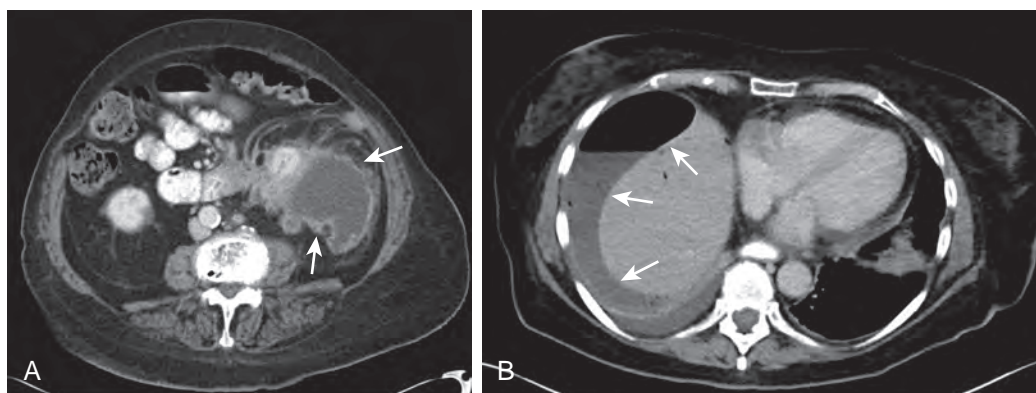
CT features of intra-abdominal abscesses in two different patients. A. Axial CT image in a 62-year-old man with perinephric abscess shows a low-attenuation collection in the left perinephric space with enhancing wall (arrows) at the periphery and mild surrounding fat stranding. B. Axial CT image in a 65-year-old woman with a postoperative abscess after laparoscopic cholecystectomy shows a perihepatic abscess with air-fluid level (arrows).
